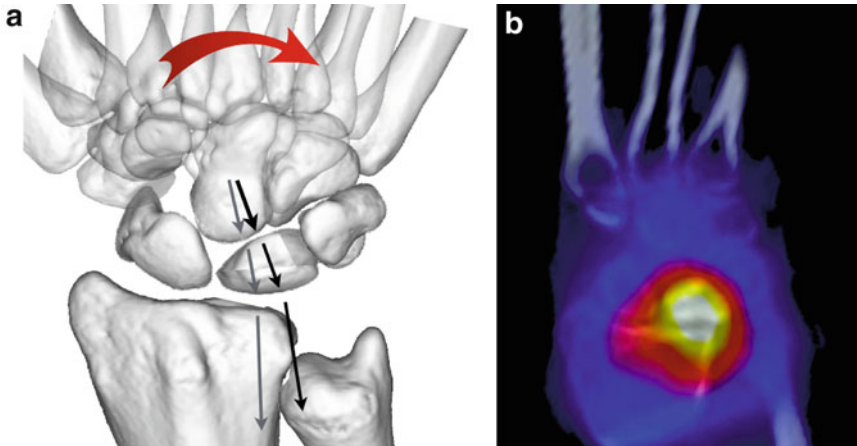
The uncovered type I lunate. (a) The uncovered type I lunate is positioned on the radial edge of the lunate, and with power grip in ulnar deviation loads on the radial edge of the radius. (b) The SPECT scan demonstrates
